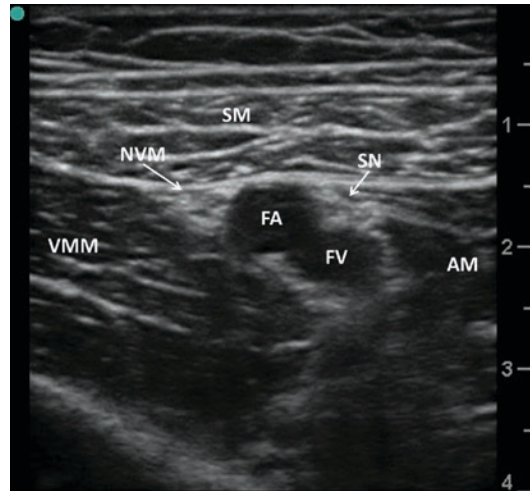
Ultrasound-guided adductor canal block. The adductor canal is formed by the vastus medialis muscle (VMM; lateral), sartorius muscle (SM; anterior), and adductor muscles (AM; posterior-medial). The saphenous nerve (SN), nerve to vastus medialis (NVM) and branches of the femoral artery and vein (FA, FV) are visualized
